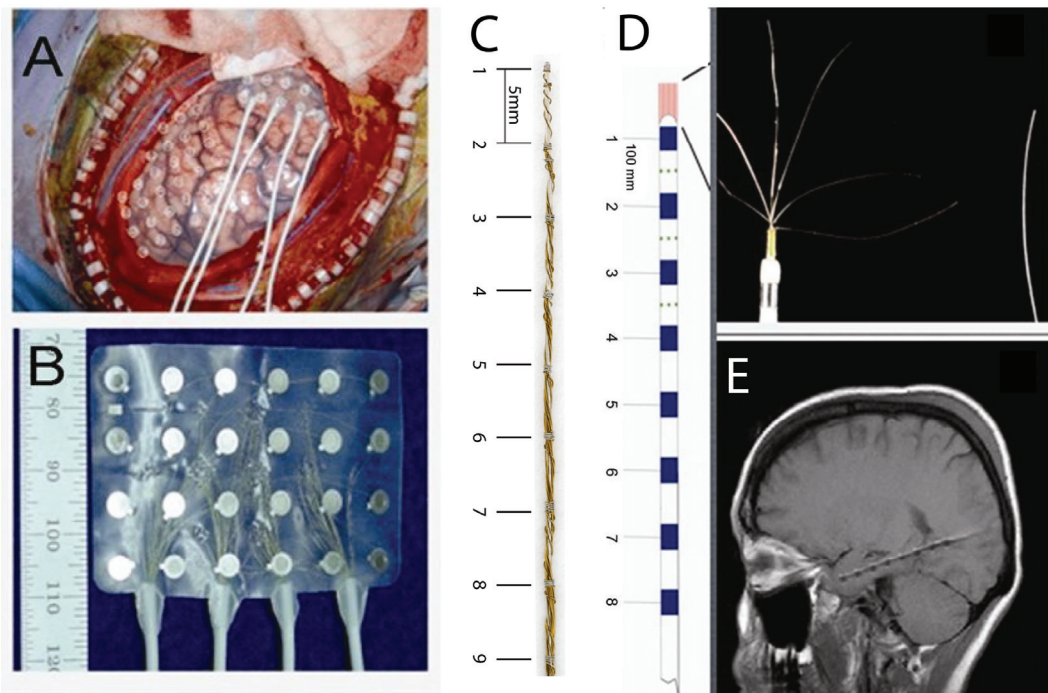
Different types of intracranial electrodes. A) Implantation of subdural grid. B) Dimensions of subdural silastic grid. C) Depth macroelectrodes fabricated on site at the Montreal Neurological Hospital. D) Depth electrode with bundle of microelectrodes at the tip of a macroelectrode. E) Post-implantation MRI shows the trace of a depth electrode. Modified from (Worrell *et al.*, 2012).
